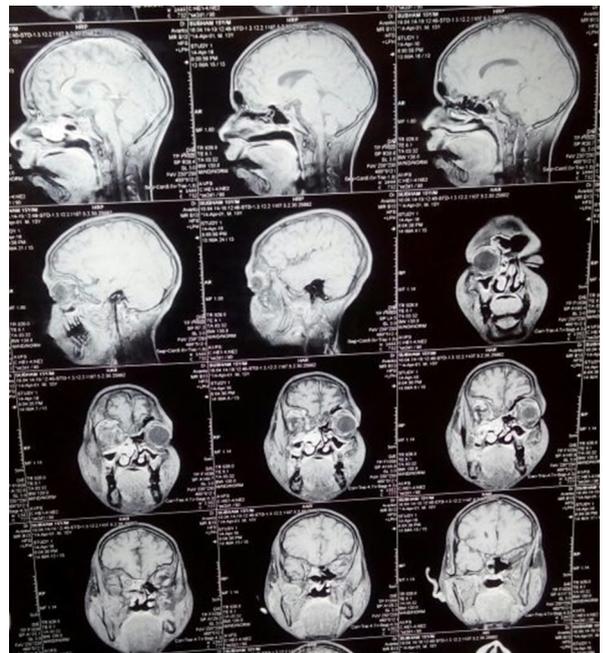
MRI Brain - T2 heterogeneously hyperintensity right maxillary sinus extending into right osteomeatal complex and right nasal cavity posteriorly
